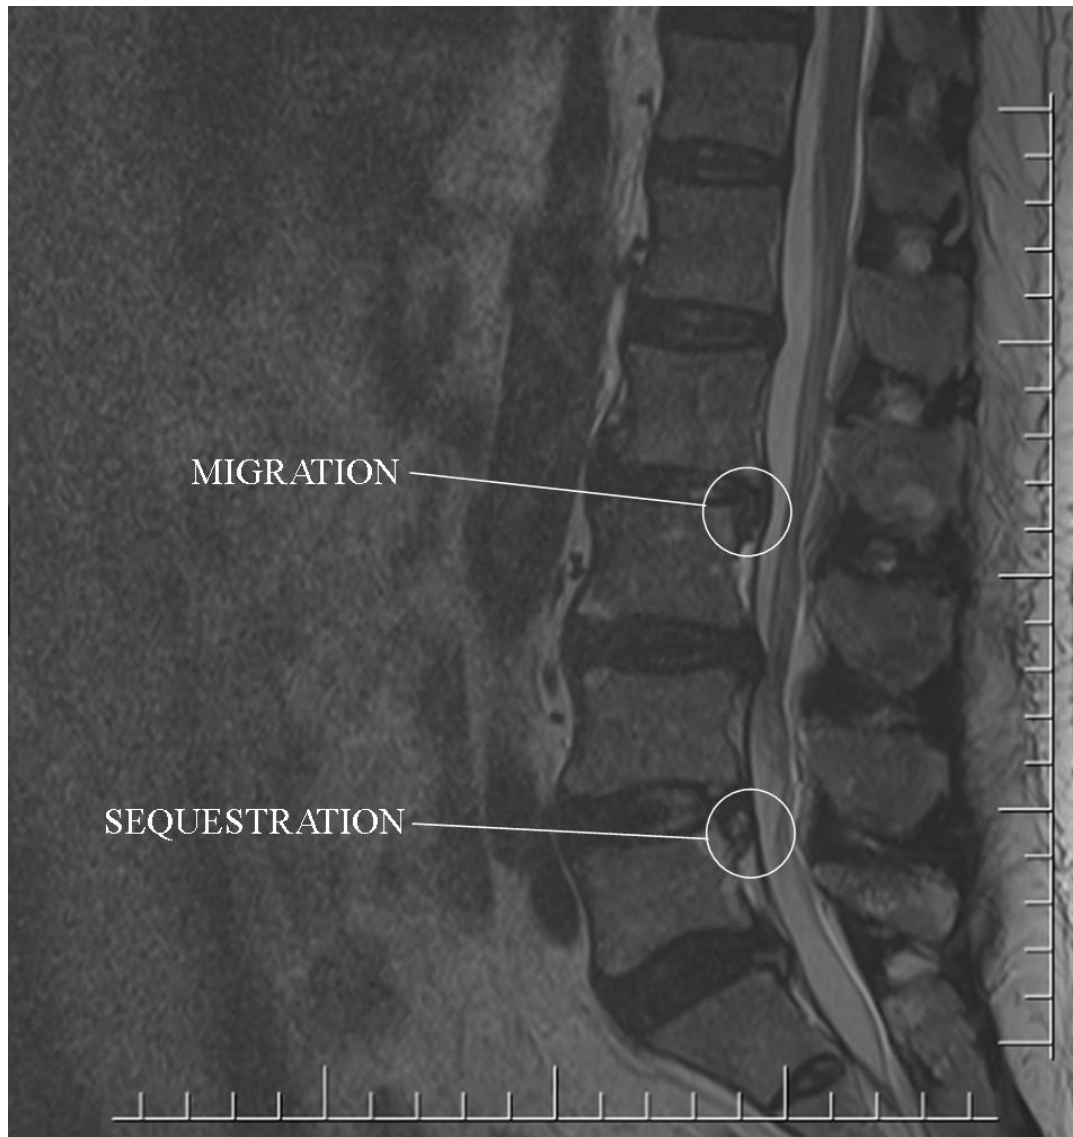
MRI of the lumbar spine showing Migration (displacement of disc material away from the site of extrusion) and Sequestration (displaced disc material that has lost completely any continuity with the parent disc).
